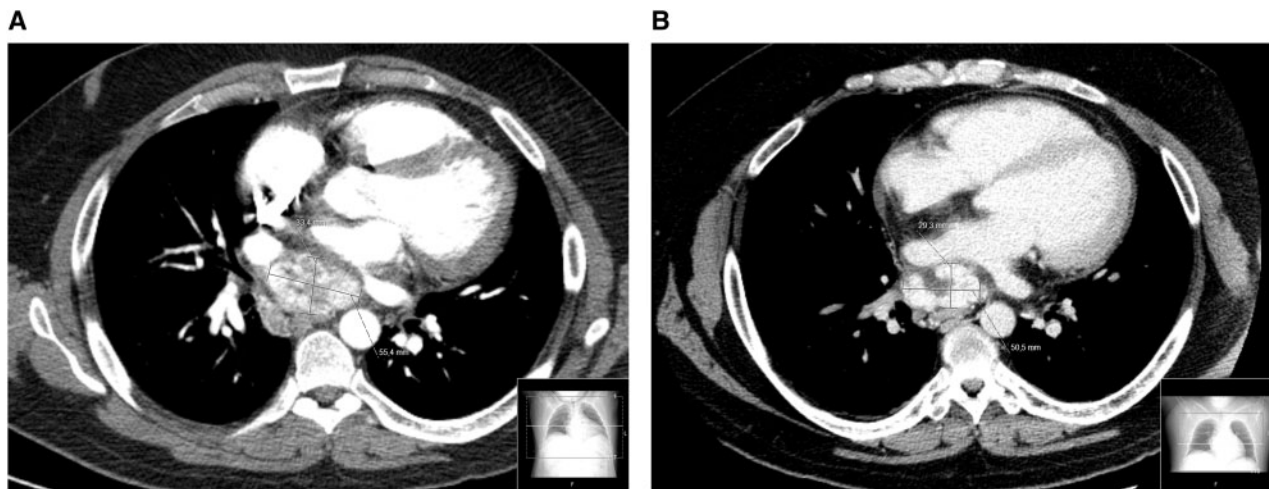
(A) Computed tomography contrast scan showing a heterogeneous mass of 6.1×5.3 cm in close proximity with the pulmonary arteries, the aorta, and the left atrium, with mass effect. Imaging characteristics were consistent with a mediastinal paraganglioma. (B) Follow-up computed tomography contrast scan (11 months after embolization): confirmed the successful embolization of the left circumflex coronary anomalous feeder branch and a slight decrease in tumour size from the initial to $61 \times 53 \times 33$ mm to $59 \times 50 \times 29$ mm.
